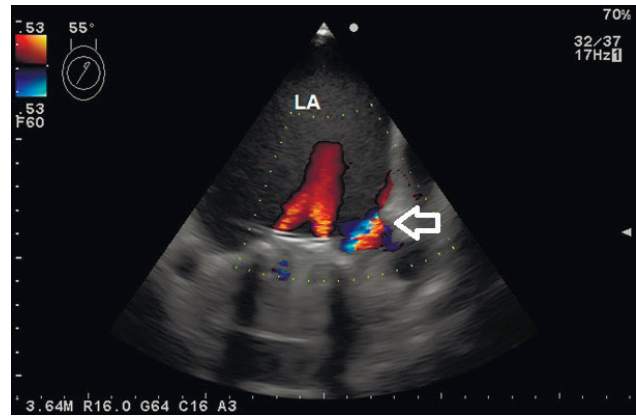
Transesophageal two chamber view demonstrating small mitralparavalvularleak (arrowhead).
